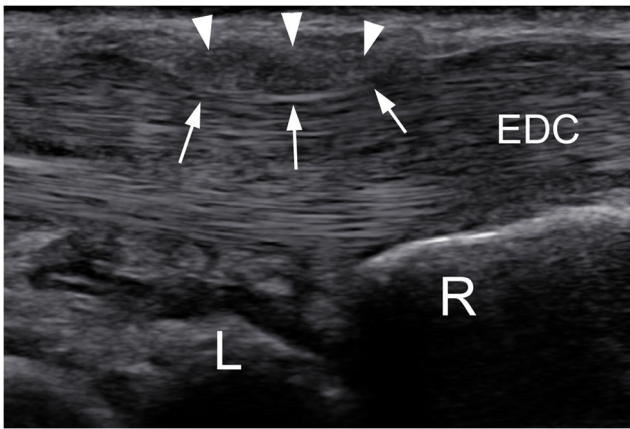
Ultrasound dynamic examination of EDCST in the same patient as Fig. 4. Sagittal ultrasound image obtained with active finger extension. Focal compression (arrows) of the hypoechoic thickened ER (arrowheads) on the underlying EDC. (L, lunatum; R, radius)
